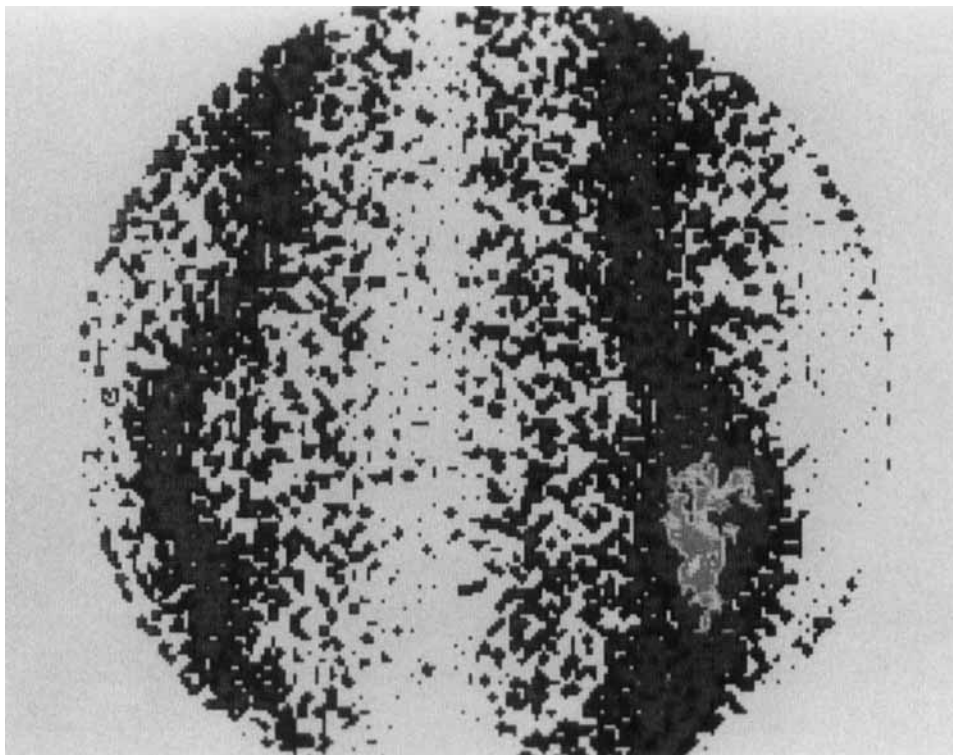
Indium 111-labeled platelet scintigraphy.
